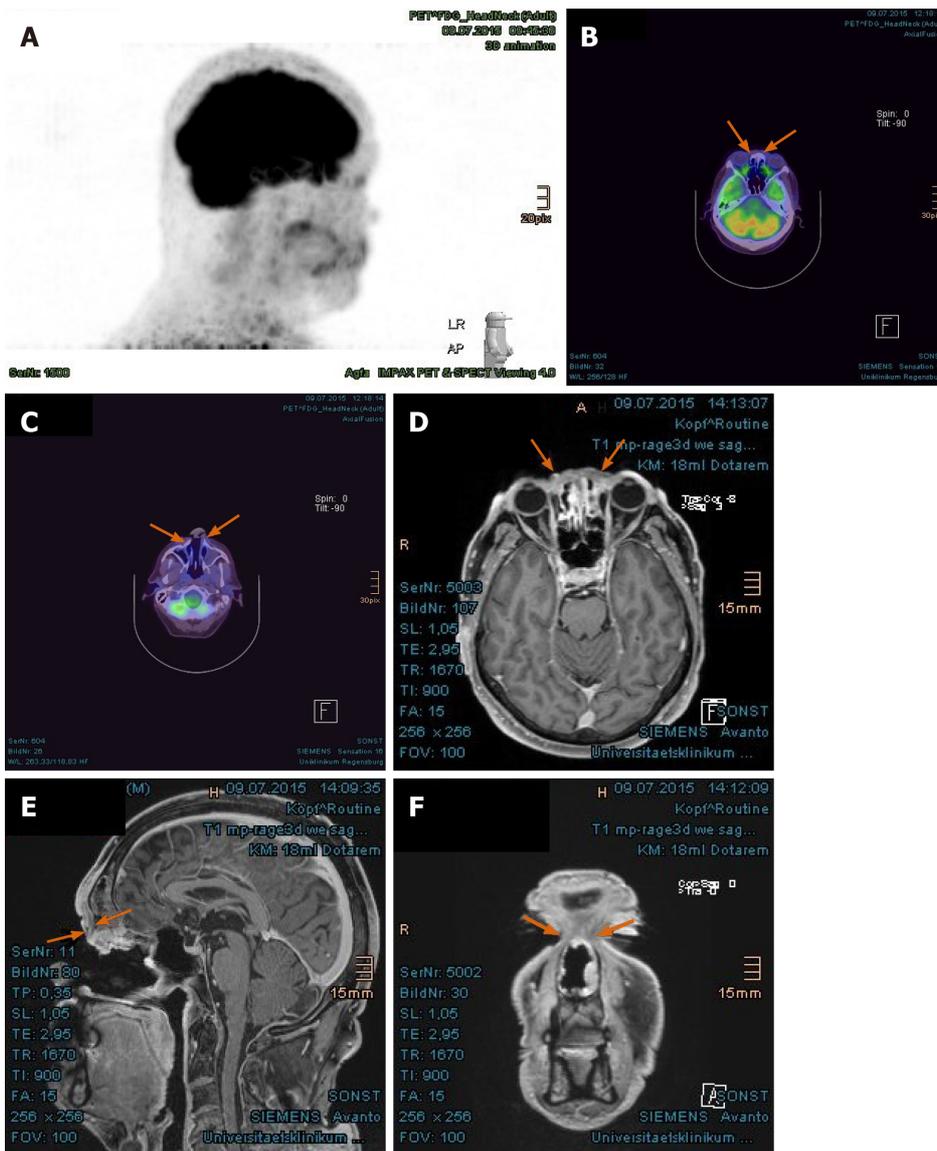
Complete tumor remission demonstrated in the positron emission tomography with 2-deoxy-2-fluorine-18-fluoro-D-glucose/computed tomography and magnetic resonance imaging at 8 mo after proton beam therapy. A: No pathologically increased activity in the positron emission tomography, overview image; B: Absence of increased fluoro-D-glucose avidity in the nasal bridge (arrow-marked in positron emission tomography/computed tomography); C: Absence of metabolically active tumor in the nostrils; D: Corresponding area in the nasal bridge in magnetic resonance imaging, presented in axial plane; E: Corresponding area in the frontal skull base, presented in sagittal plane; F: Coronal presentation of tumor remission in the nasal bridge. Previously enhancing tumors marked with arrows.
